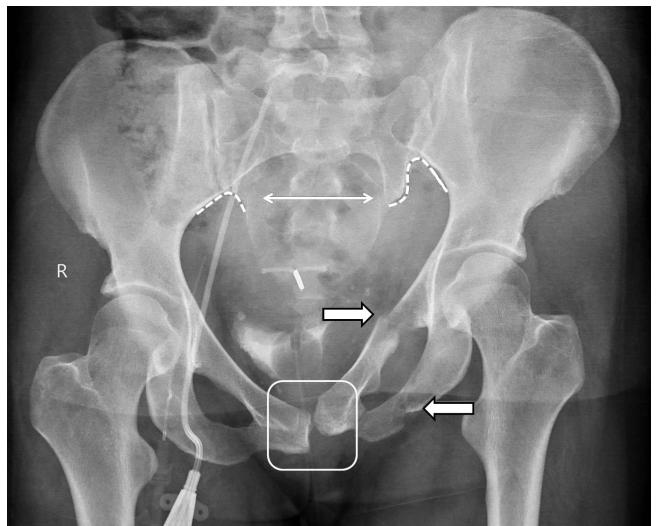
AP Pelvis radiograph demonstrating marked vertical displacement of the left hemipelvis (broken curves and arrow), with superior and inferior pubic remus fractures (full thickness arrows), and mild displacement of the pubic symphysis (rectangular box).
